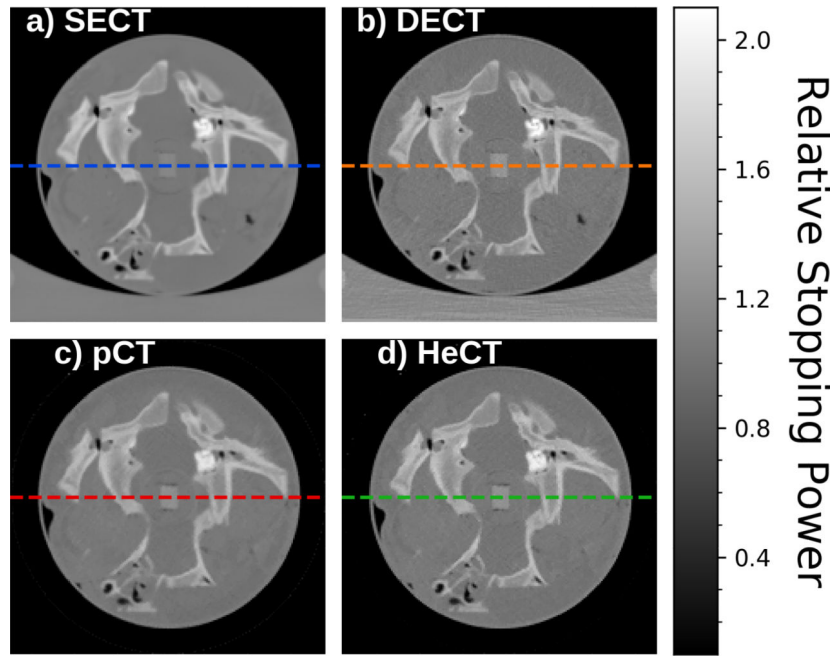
Slice through the reconstructed CT scans from a) SECT, b) DECT, c) pCT and d) HeCT. Note, the HeCT was reconstructed from 360 projections separated by 1° steps and the pCT from 180 projections separated by 2° steps
